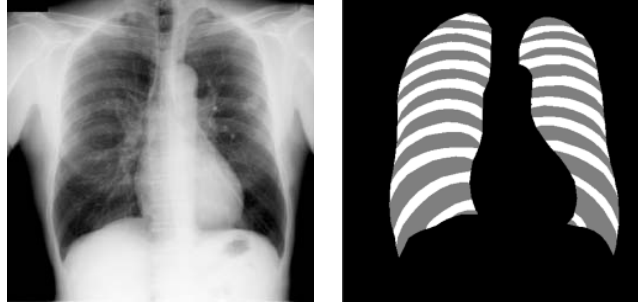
Images showing segmentation of ribs (Loog et al., 2006), where the image on the left is the original chest radiograph and the image on the right is the segmented image. Black is background area, grey is intercostal space and white is costal space.
